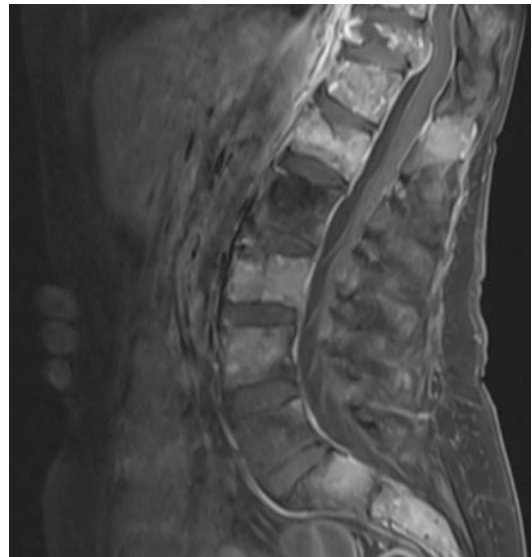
Lumbar MRI of patient with diffusely metastatic breast ductal carcinoma demonstrating several pathologic fractures and cord compression at T11
